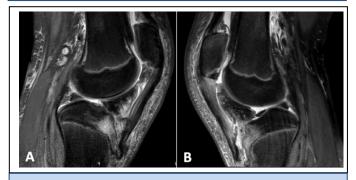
Sagittal T2-weighted MRI of the right (A) and left (B) knee show patella alta with disruption of the patellar tendon fibers in the form of delamination shear injury consistent with distal tendinous disruption from its bony attachment.
